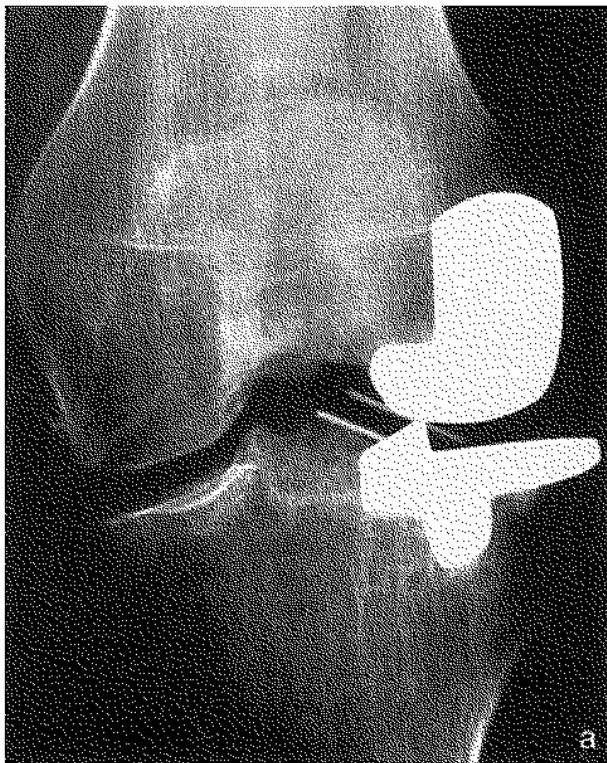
AP and lateral radiographs showing a medial dislocation of the meniscal bearing in a lateral compartment arthroplasty.
